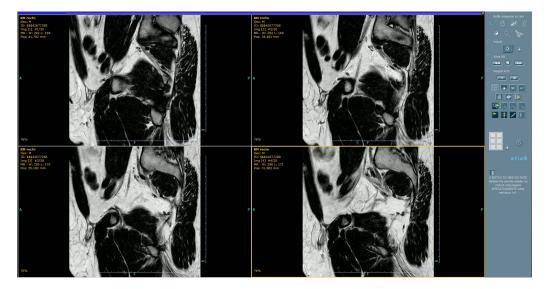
MR images consulted during the preoperative meeting.
